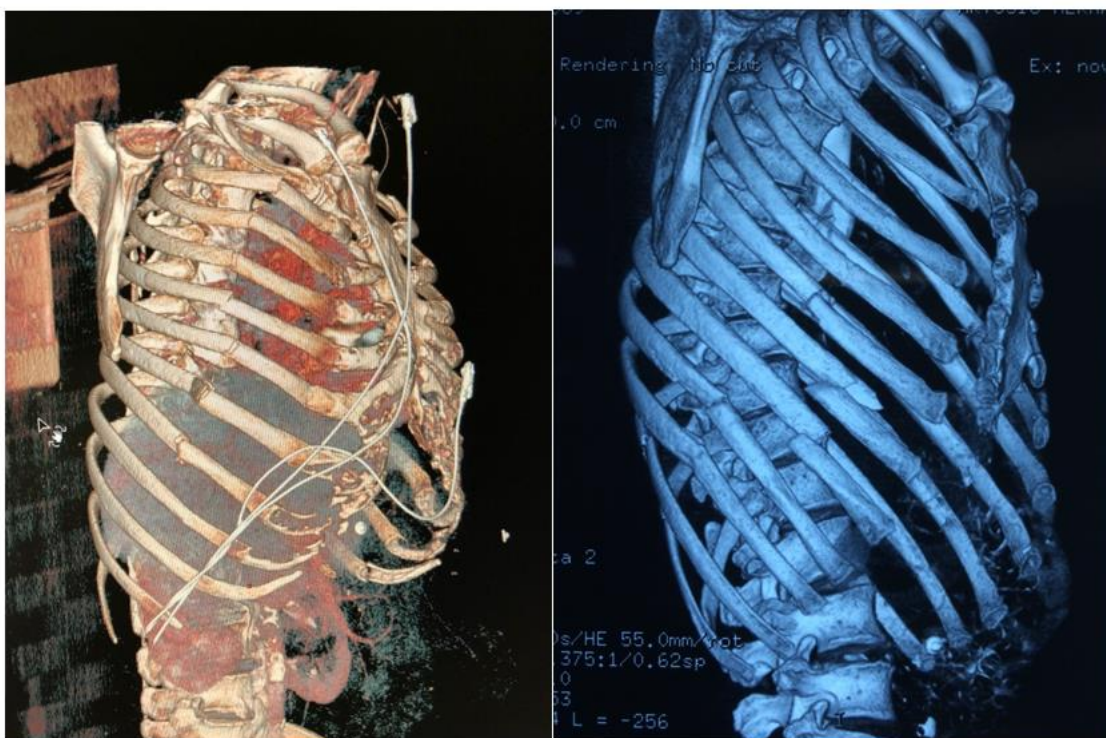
3D CT to evaluate rib fractures number and localization
